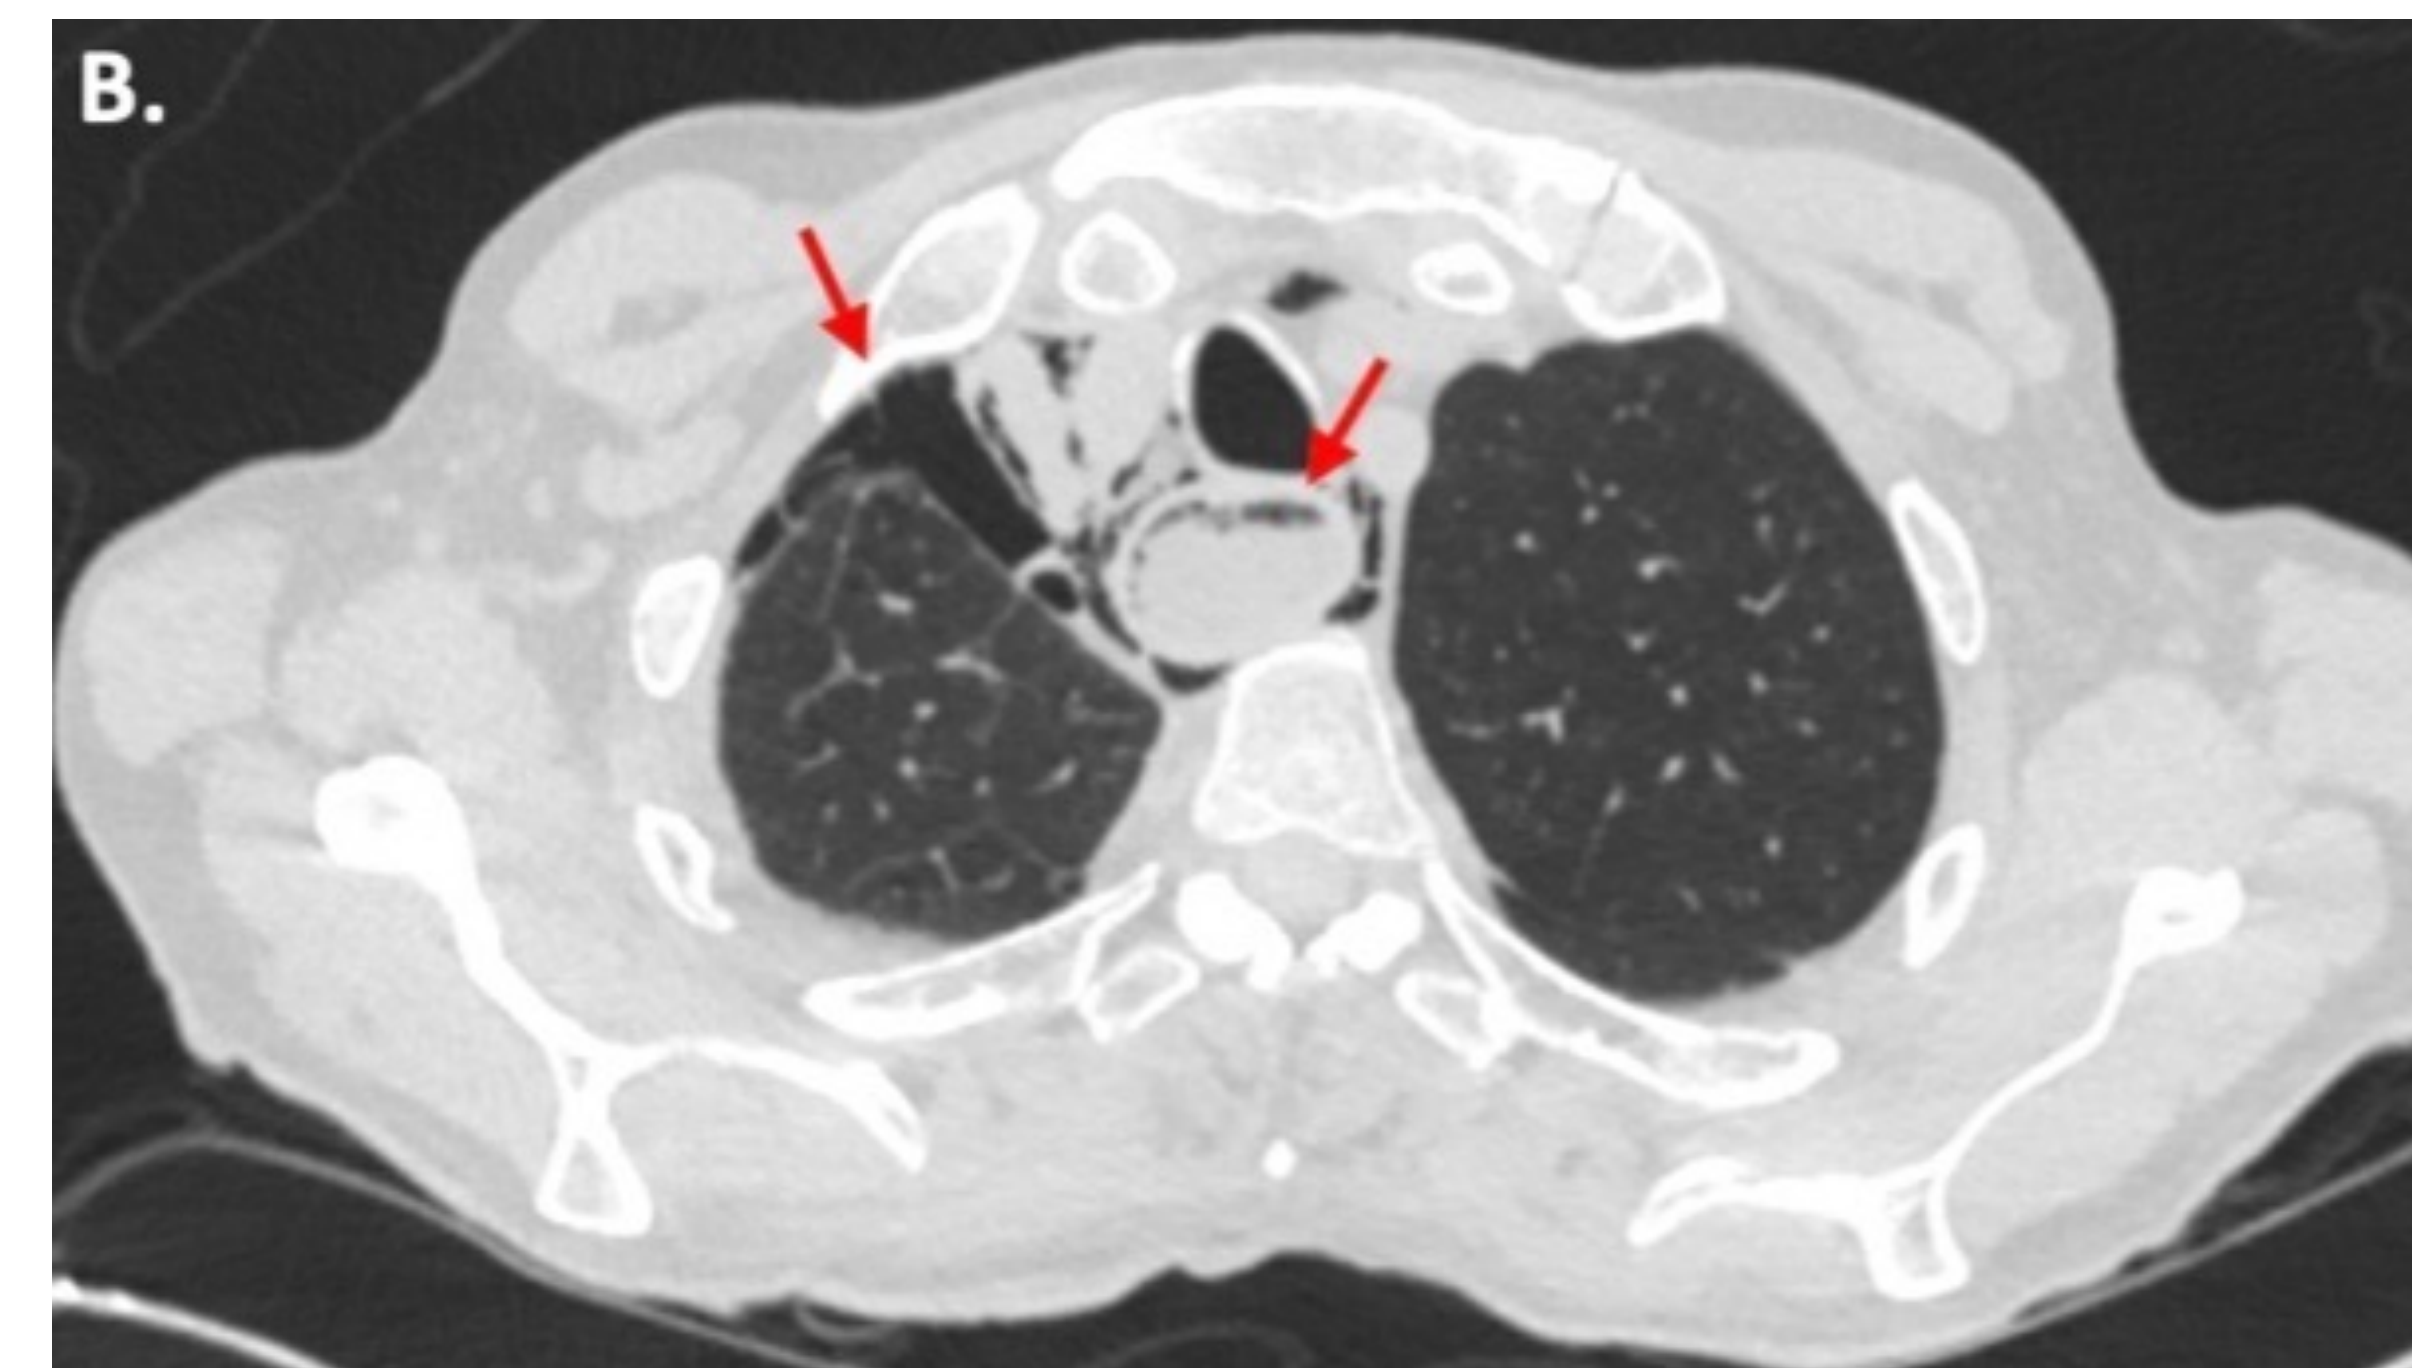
Repeat CT Chest remarkable for a moderate volume pneumomediastinum and a small to moderate size right pneumothorax
